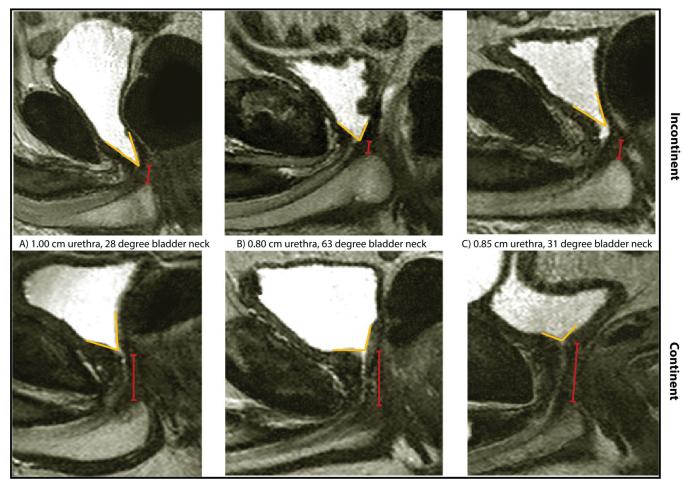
Examples of sagittal MRI measurements of urethral sphincter length and bladder neck angle in three incontinent men (A–C) and three continent men (D–F).
